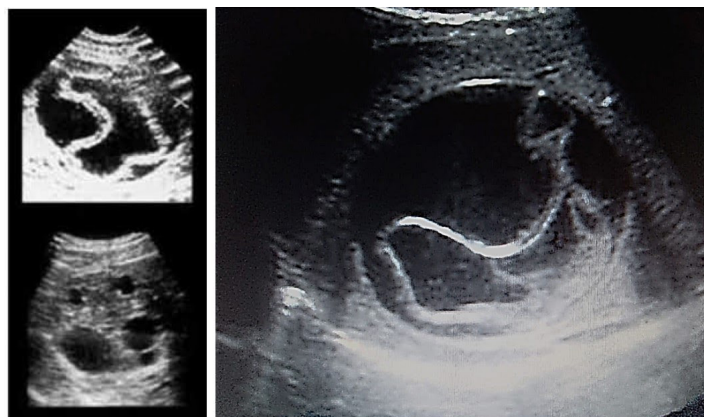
Compared ultrasonography images of cystic echinococcosis CE3a type between WHO-IWGE classification and positive patient liver from Salerno province.
